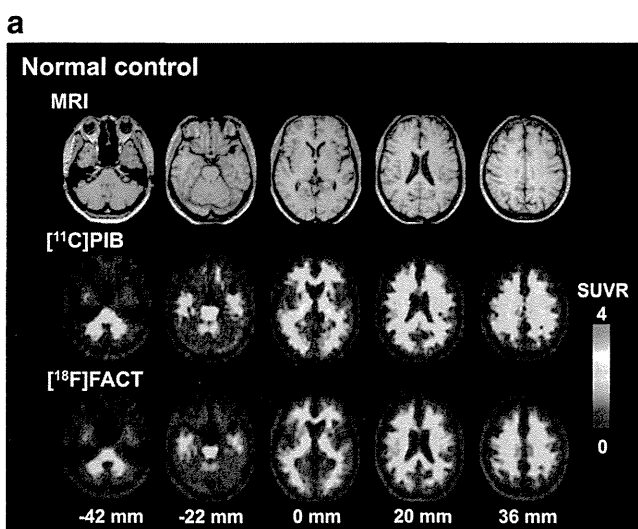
Typical SUVR images of $[^{11}\text{C}]\text{PIB}$ and $[^{18}\text{F}]\text{FACT}$ studies and corresponding MR images (T1-weighted images) for a normal control subject (a) and an AD patient (b). Scale maximum and minimum values are 4 and 0 of SUVR. All images are transaxial sections parallel to the anterior-posterior commissure (AC-PC) line. Slice positions are -42 , -22 , 0 , 20 , and 36 mm from the AC-PC line. Anterior is at the top of the image and the subjects' right is on the left
